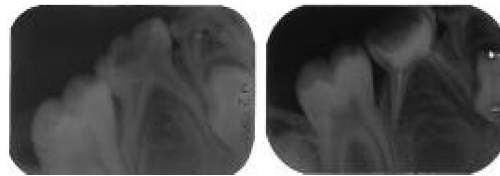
(a,b) Apical Radiographs of the teeth (both sides) following gutta percha root filling
